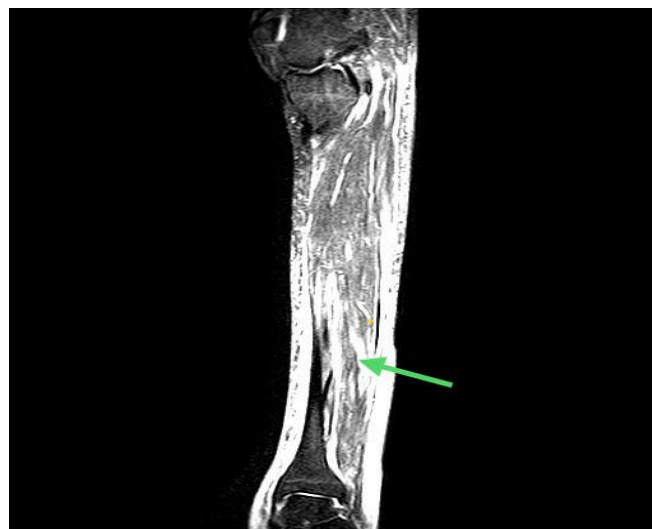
MRI Lower Limb Showing Myositis (Green Arrow)
